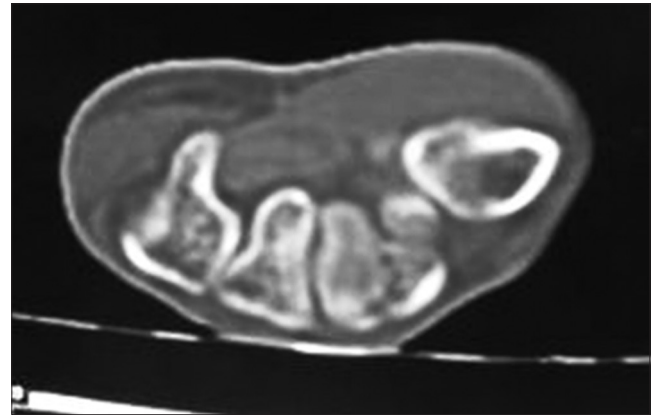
CT axial scan of Right wrist joint showing fracture of Trapezoid bone
